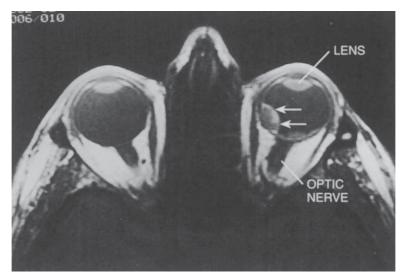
Axial T1W magnetic resonance image of a patient with choroidal malignant melanoma of the left eye (*arrows*). MR images allow simultaneous evaluation of both orbits. Orientation on an MR image is placed as though the examiner were looking up from the feet of the patient, so that the image of the left eye is placed on the right-hand side when looking at the film.
